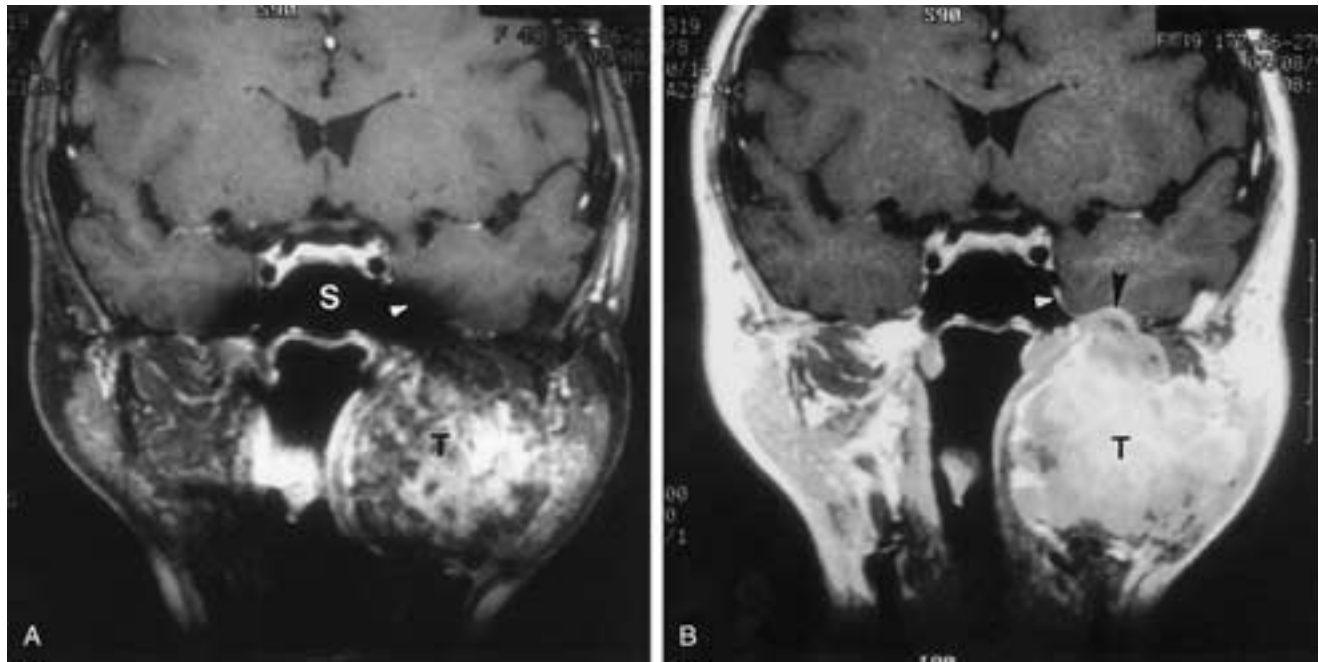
Very large benign tumor of the parotid gland extending through the floor of the middle cranial fossa. A, Coronal T1-weighted MR image with fat suppression after gadolinium administration. The tumor (*T*) can be readily visualized. The sphenoid sinus (*S*) is filled with air. The air causes “blooming” of the sinus laterally (*arrowhead*), obscuring the lower cavernous sinus in the region of the foramen ovale. This is due to the susceptibility effect. B, Without fat suppression, on a T1-weighted image after gadolinium administration, the lateral margin of the sphenoid sinus (*arrowhead*) is much better seen, as is the lower cavernous sinus. A small amount of tumor obscured with the previous image is well seen (*arrowhead*) protruding into the middle cranial fossa. *T*, Tumor.
